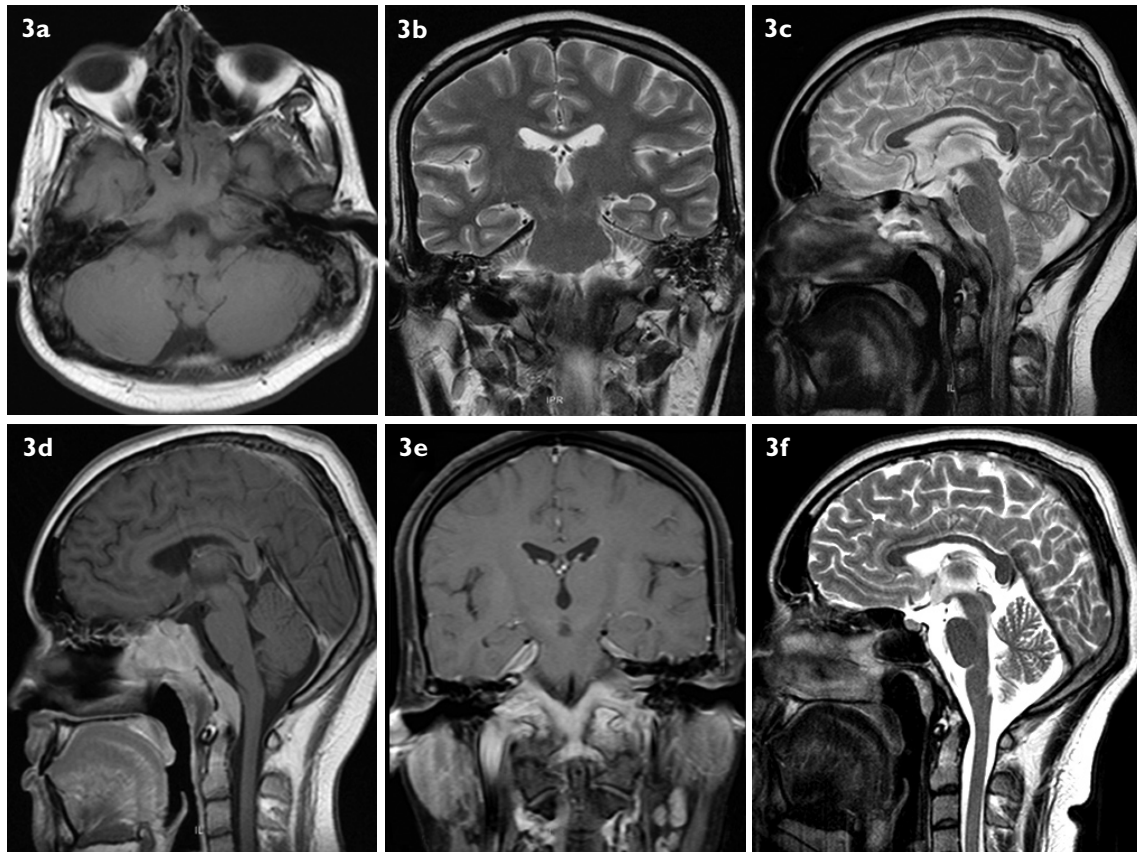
(a) Axial T1-W MR image of the brain basal shows isointense mucosal thickening of the phenoid sinus and retroclival pachymeninges. (b) Coronal T2-W MR image taken at the level of the tentorium shows thick hypointense tentorial thickening. (c) Midline sagittal T2-W MR image shows thick lobulated retroclival pachymeningeal thickening. (d) Contrast-enhanced sagittal T1-W MR image taken in the midline shows an enhancing sphenoid sinus and lobulated retroclival pachymeningeal thickening. (e) Contrast-enhanced coronal T1-W image taken at the tentorium level shows a thick enhancing tentorium. (f) Post-treatment follow-up sagittal T2-W image does not show retroclival pachymeningeal thickening and sphenoid sinusitis.
